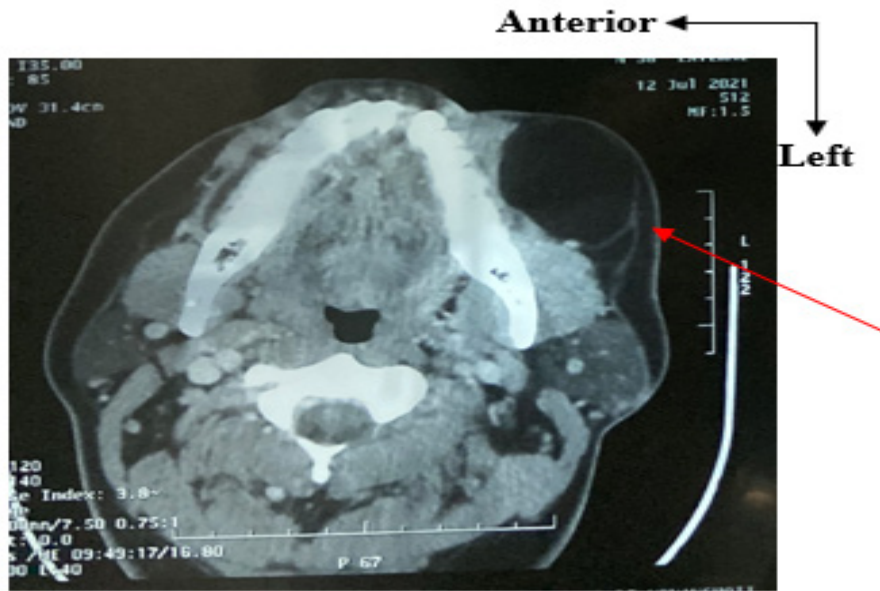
CT scan emphasized hypodense image on left jugal area (axial section).
